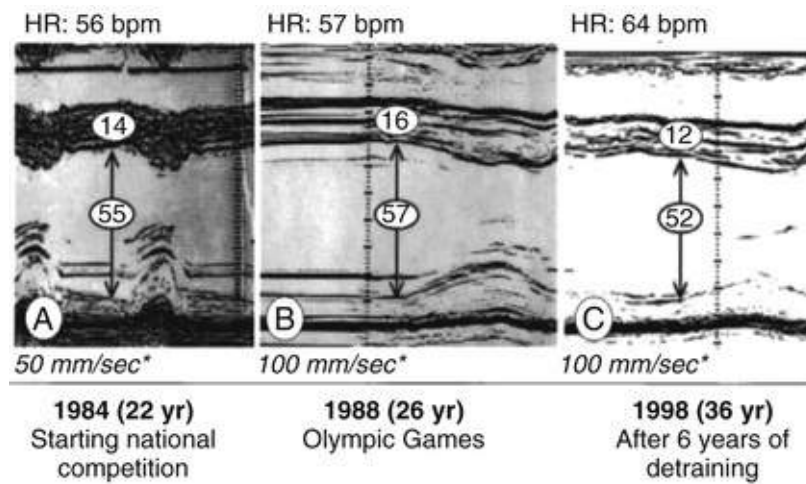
Serial echocardiograms from an elite canoeist at 22 years of age, when he joined the Italian national team; at 26 years of age, when he competed in the Olympics; and at 36 years of age, after 6 years of detraining; *bpm*, beats per minute; *ovals* show measurements in millimeters. *Paper speed. (From Pelliccia A, Maron BJ, Di Paolo FM, et al. Prevalence and clinical significance of left atrial remodeling in competitive athletes. *J Am Coll Cardiol* 2005;46:690.)
